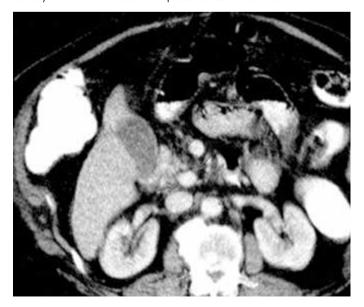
CT image of one patients shows hyperdense nodule is seen within posteromedial portion of pancreatic head
